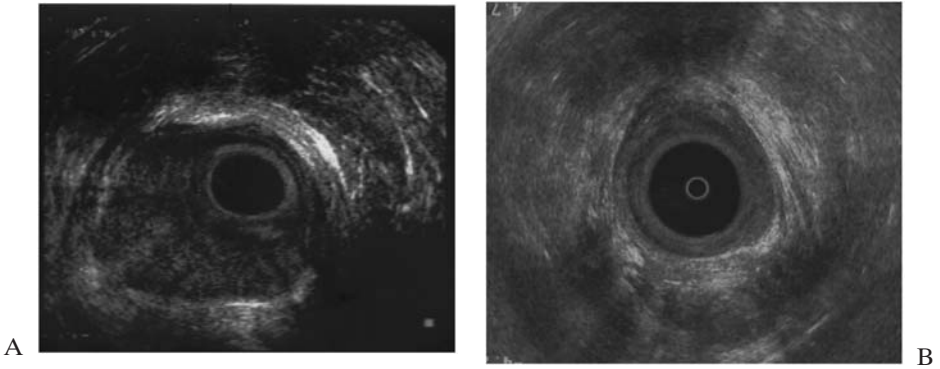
(A) Pre-chemoradiation therapy. (B) Eighteen months post-chemoradiation therapy. (Ultrasound images courtesy Dr. Julio Garcia-Aguilar.)
